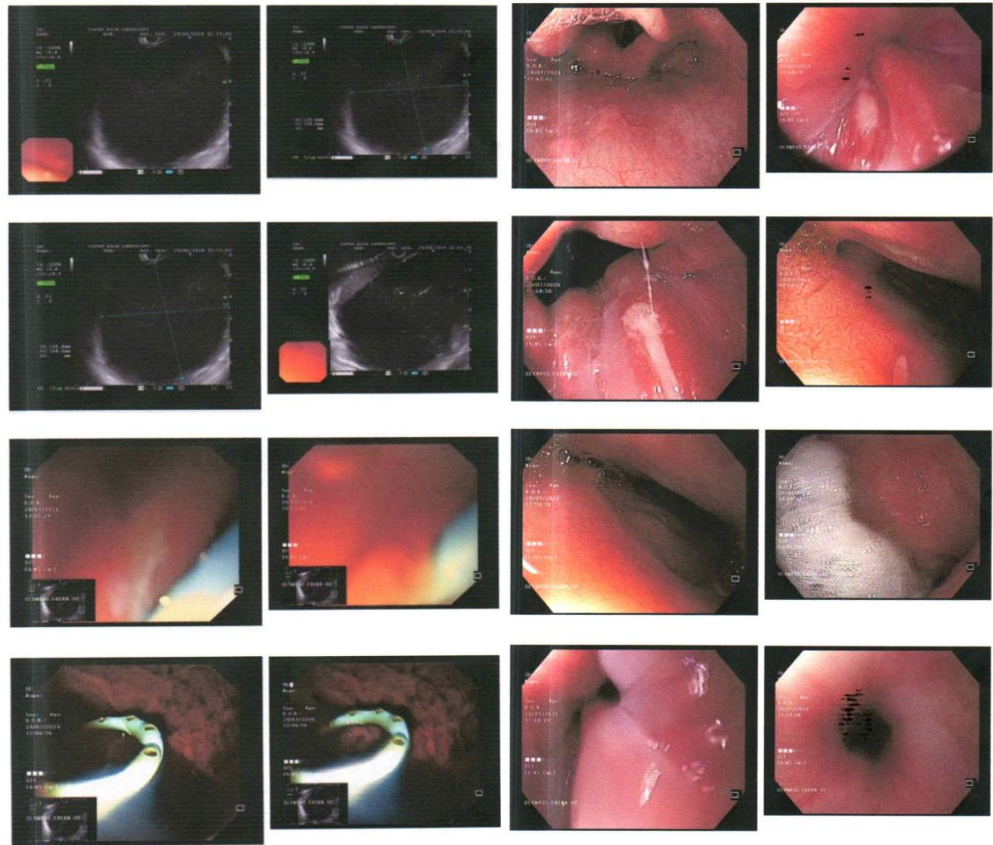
Endoscopic Ultrasound (EUS) and Esofagastroduodenoskopi (EGD)
